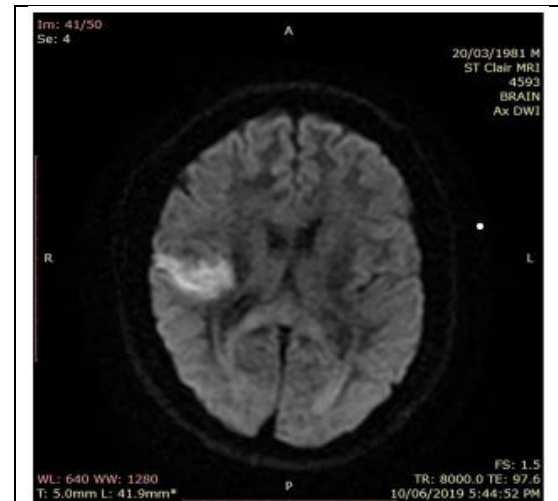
Right parietal lobe hyperintensity around the Sylvian fissure is shown on an axial DWI MRI.
